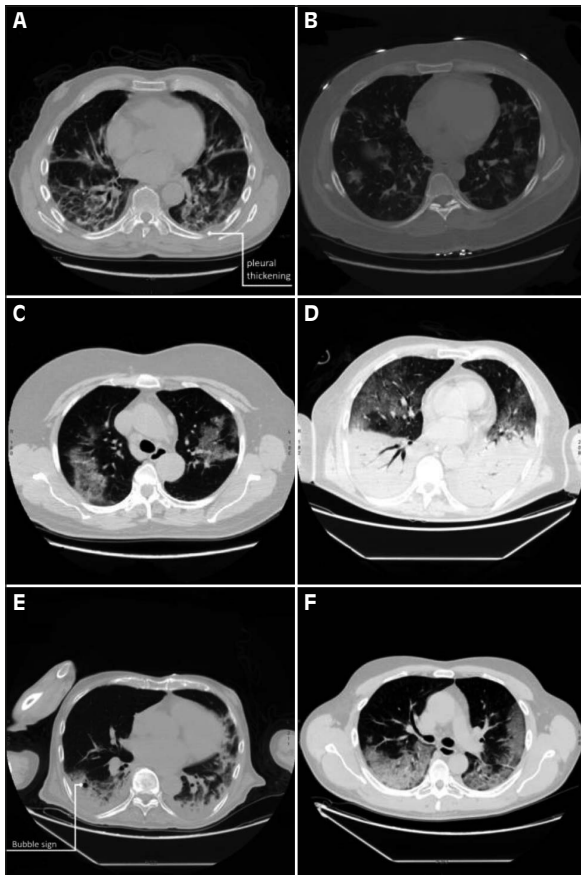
Radiological lesions observed at chest CT scan of patients with COVID-19 pneumonia; 1a) reticular pattern associated with pleural thickening; 1b) GGOs; 1c) crazy paving; 1d) consolidation pattern with air bronchogram; 1e) consolidation with air bubble sign; 1f) crazy paving associated with vascular enlargement.
